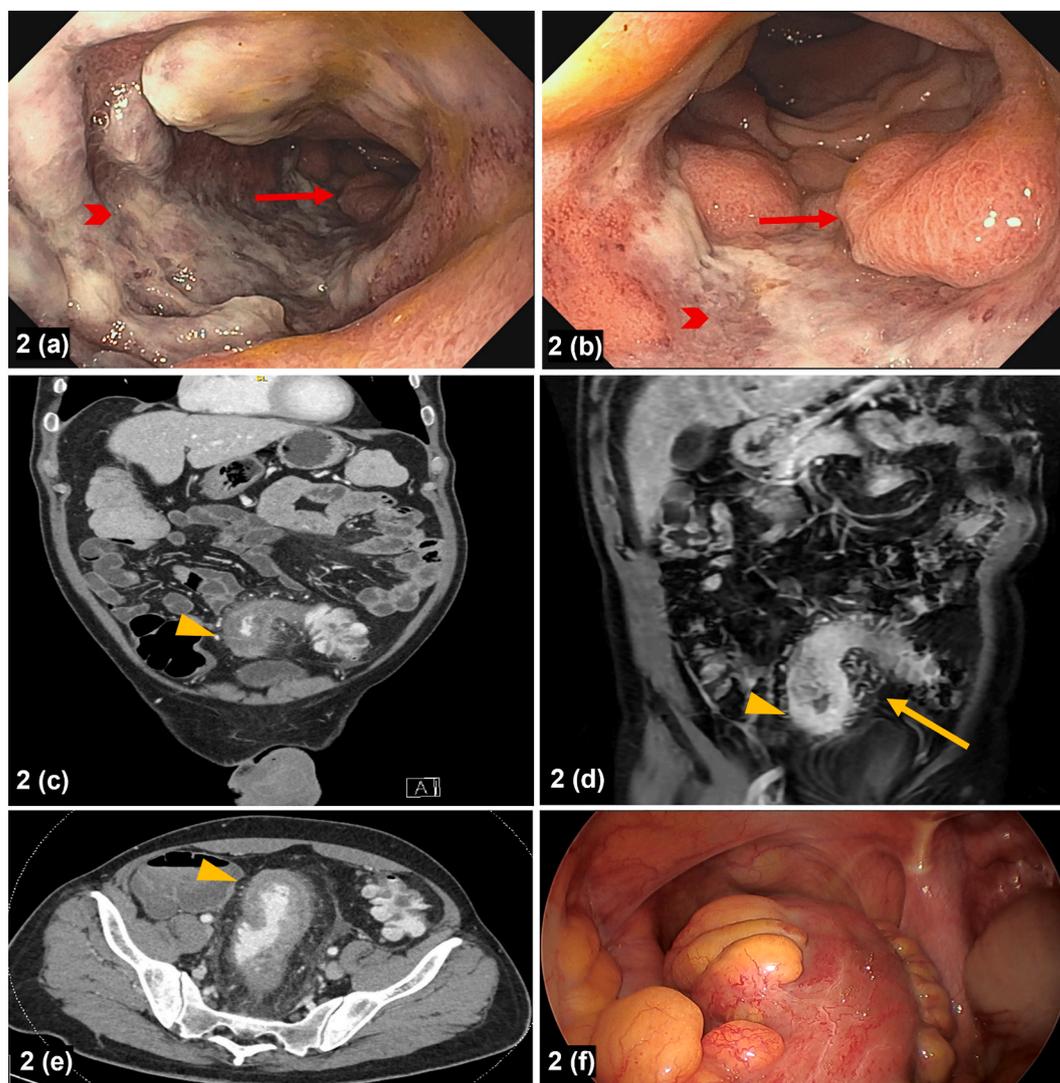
Case 2 — Endoscopic, radiographic, and intraoperative imaging findings of IMHMV.
